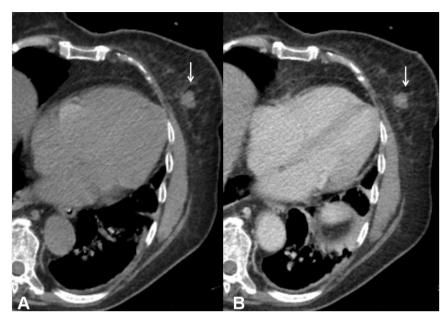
Incidental left breast mass lesion detected with chest CT. A. Non- Contrast chest CT. A left breast lesion was noted (arrow) showing lobulated contour and irregular margins measuring a maximum diameter of 1.3cm. B. Contrast- enhanced chest CT. The mass (arrow) exhibited mild enhancement following intravenous contrast. The left breast background was adipose-rich and comprised sparse fibroglandular tissue.
